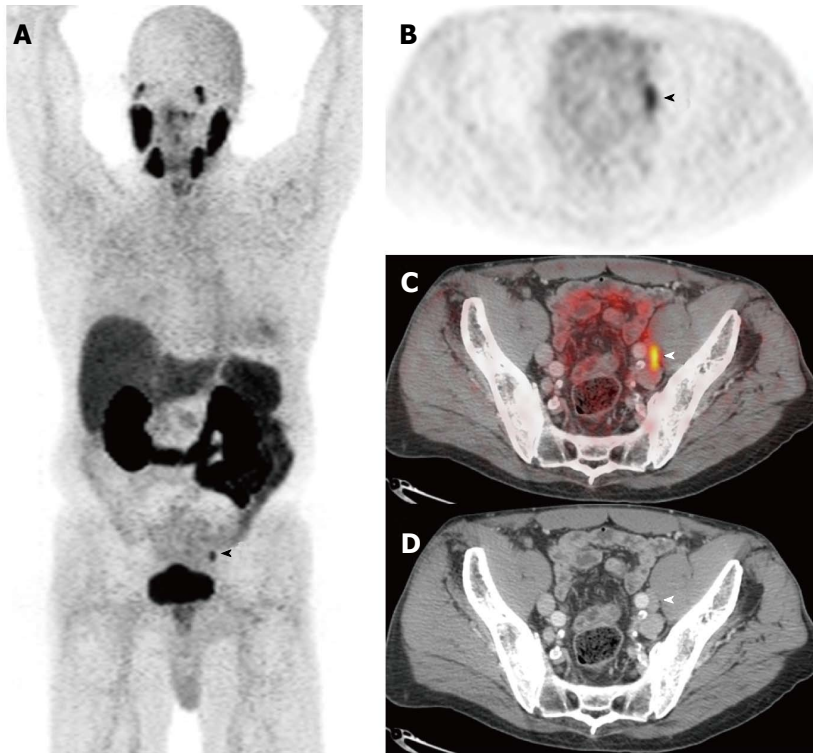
Prostate specific membrane antigen. Selected images from a [^{68}Ga]PSMA-11-PET/CT study performed prior to therapy in a man with biopsy-proven Gleason 9 prostate adenocarcinoma, a serum PSA of 11.6 ng/mL, and a clinical tumor stage of cT2b. The anterior maximum intensity projection (MIP) image (A) and the axial PET (B), fusion (C), and CT (D) images through the pelvis demonstrate focal activity in a left external iliac lymph node. This appearance is highly suspicious for a lymph node metastasis. Images courtesy of Tom Hope, MD, University of California San Francisco, Department of Radiology. PSMA: Prostate specific membrane antigen; PET/CT: Positron emission tomography/computed tomography.
